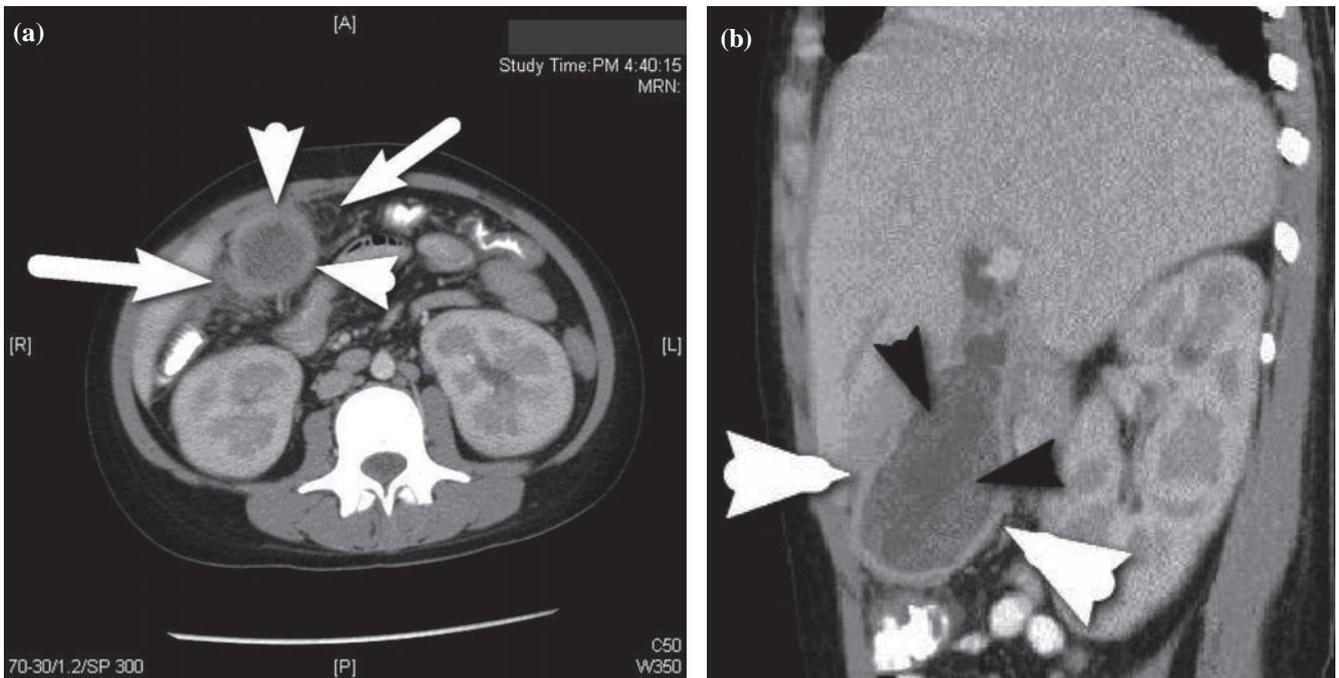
(a) An axial contrast enhanced CT image of the abdomen showed diffuse gallbladder wall thickening (white arrowheads) and pericholecystic soft tissue strandings (white arrow). (b) A sagittal reformatted contrast enhanced CT image showed gallbladder wall thickening (white arrowheads) and dense filling defects (black arrowheads) suggestive of sludge within the distended gallbladder. No gallstone was found.
